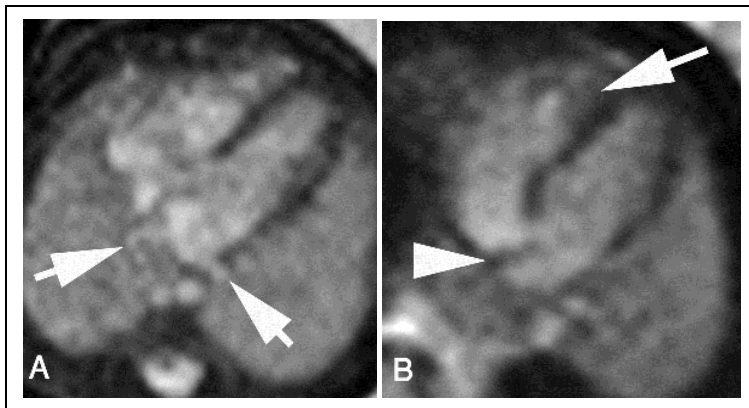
MRI anatomy of fetal heart at 28 weeks' gestation along long cardiac axis (A) and 4-chamber view (B). In (A), arrows point to pulmonary veins. In (B), moderator band (arrow) appears as low signal intensity structure between the apical right ventricular septum and free right ventricular wall. Atrial septal duct valve (arrowhead) is directed to the left indicating the normal blood direction across the foramen ovale in fetal life from right to left
